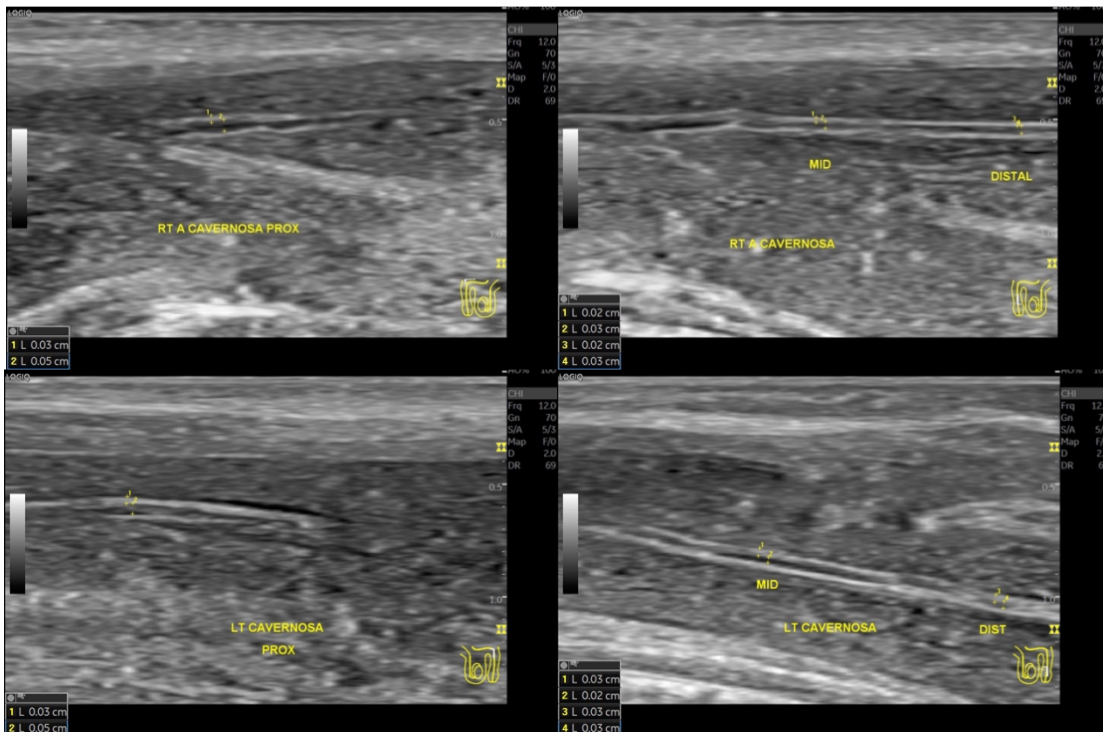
Evaluation of IMT using longitudinal greyscale ultrasound.
